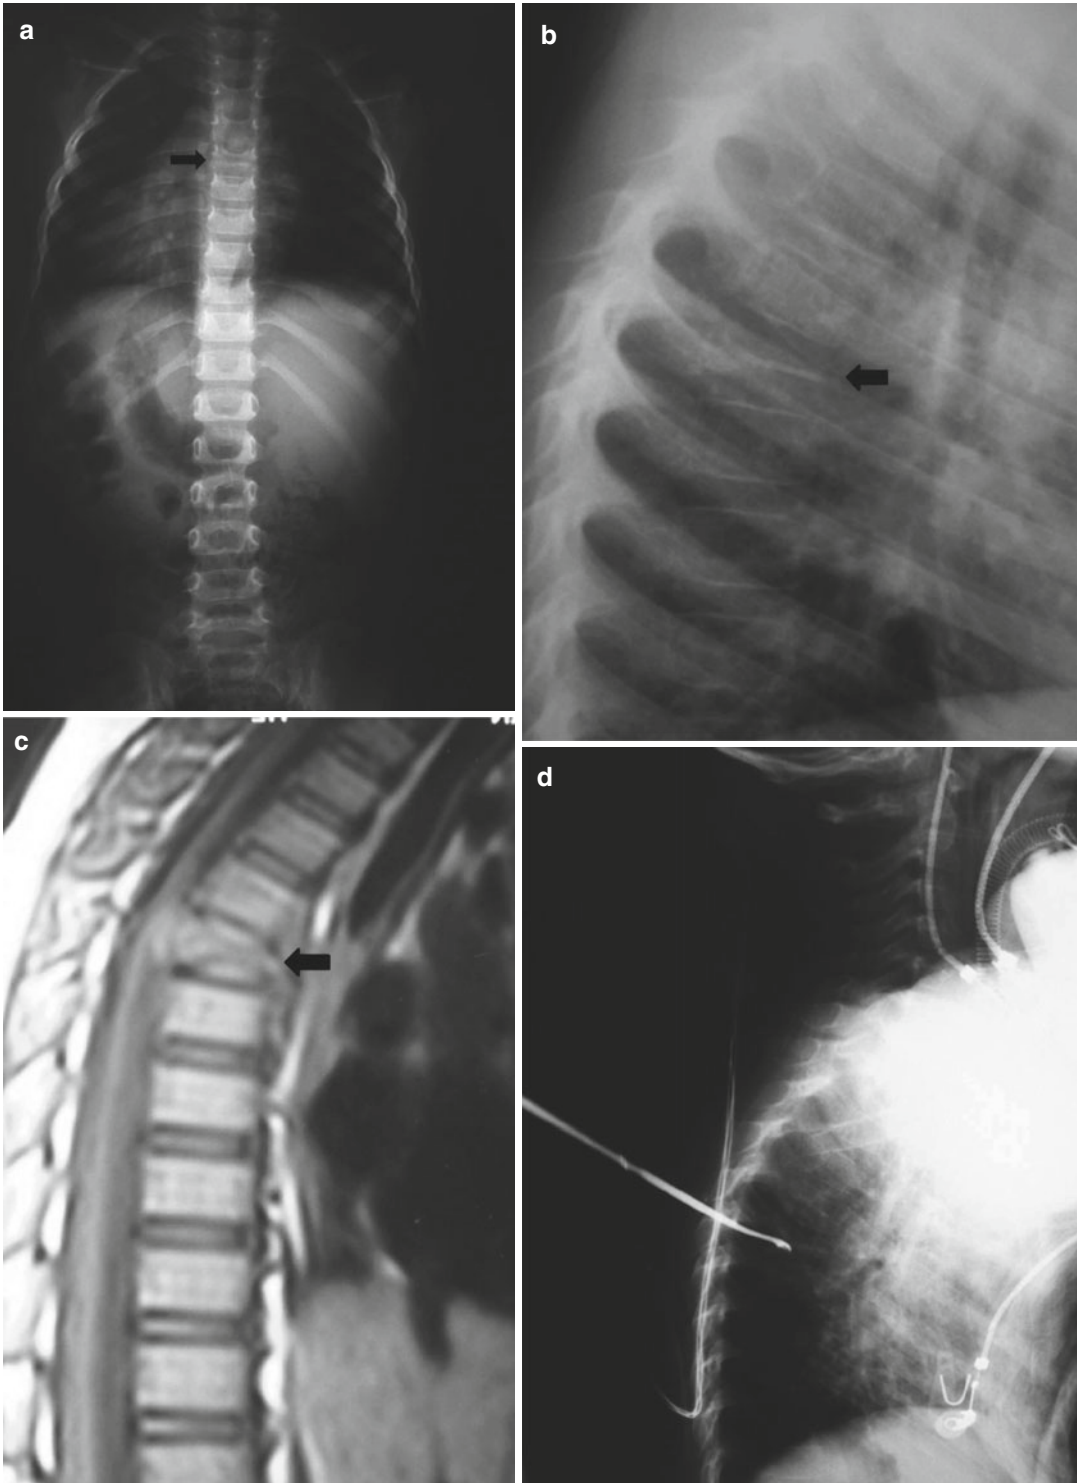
A 5-year-old male presenting with back pain. (a, b) AP and lateral plain X-rays demonstrating the typical appearance of vertebra plana (*arrow*). (c) T1-weighted
